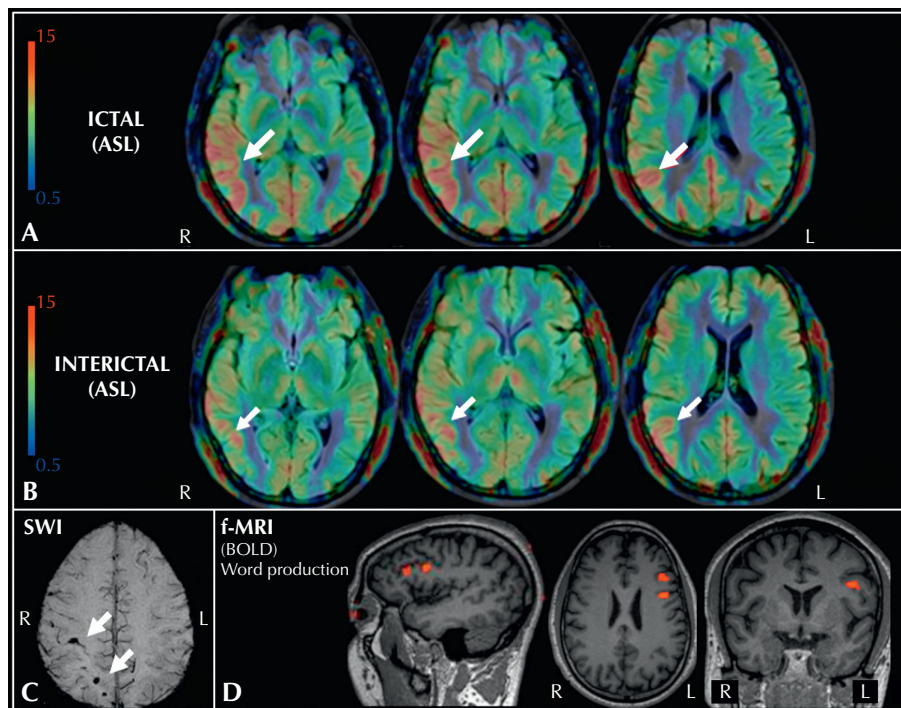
MRI study: The “hot” colours (red) seen in the arterial spin-labelled (ASL) co-registered with fluid attenuated inversion recovery (FLAIR) sequence (A) are representative of the higher relative cerebral blood flow observed in the region of interest (arrows) of the right temporal lobe in the ictal ASL map (12.1 L/100 gr/min) as compared with the contralateral side (10.8 L/100 gr/min), and to the same localisation in the interictal MRI (11.1 L/100 gr/min) (B). Reference colour scales are on the left side. Susceptibility weighted imaging shows small hemosiderin deposits in the right postcentral sulcus (C). f-MRI (Blood Oxygen Level Dependent [BOLD] fused with MPRAGE 3D) showed left opercular activation during the word generation paradigm (D). R: right; L: left.
